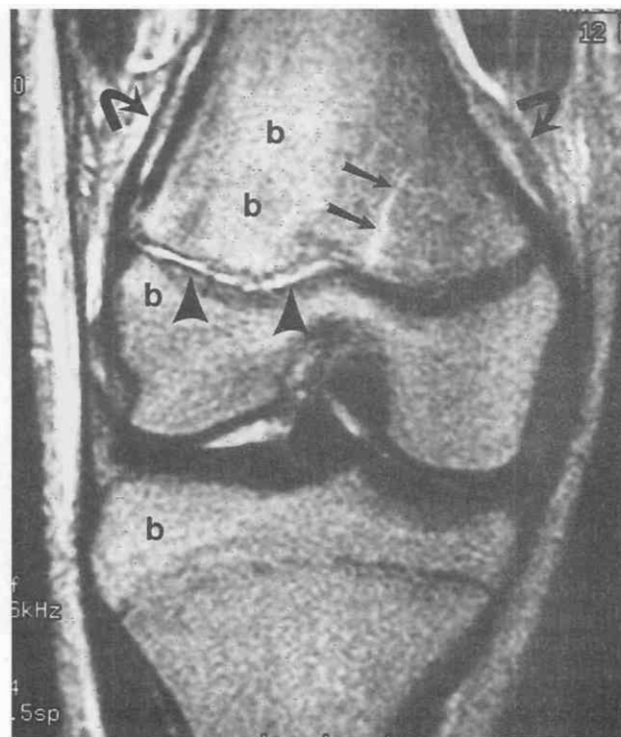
Salter II fracture of the distal femur in a 12-year-old girl. Coronal T2-weighted image (TR = 4200 msec, TE = 120 msec) delineates the fracture as a high-signal line in the metaphysis (arrows) and increased signal within the lateral growth plate (arrowheads). b, bone marrow edema. Periosteal elevation is indicated by curved arrows.
